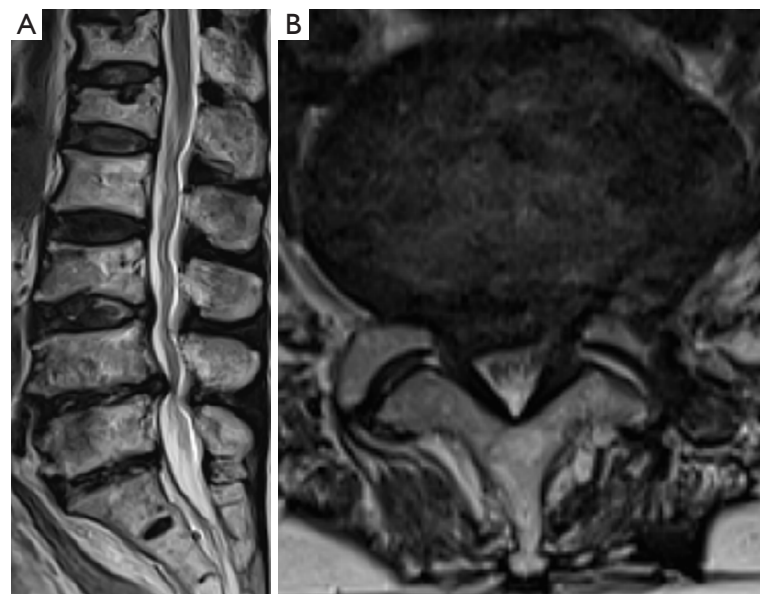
T2-weighted sagittal (A) and axial (B) magnetic resonance images show spinal stenosis with disc extrusion at the L4–5 level.
